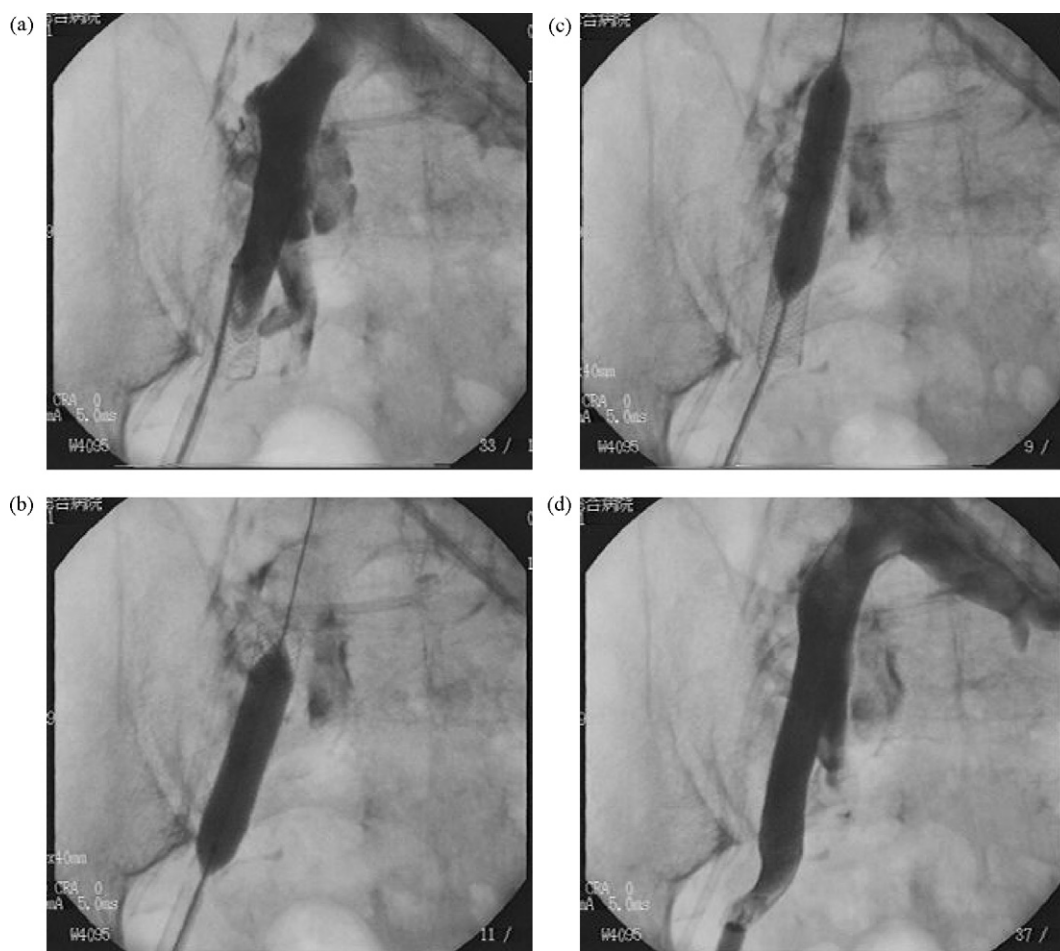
Radiographic angiograms showing contrast media leaked to the outside of the right external iliac vein (a), stent implantation and optimal-sized balloon inflation in the iliac vein (b and c), and after the balloon angioplasty (d).
